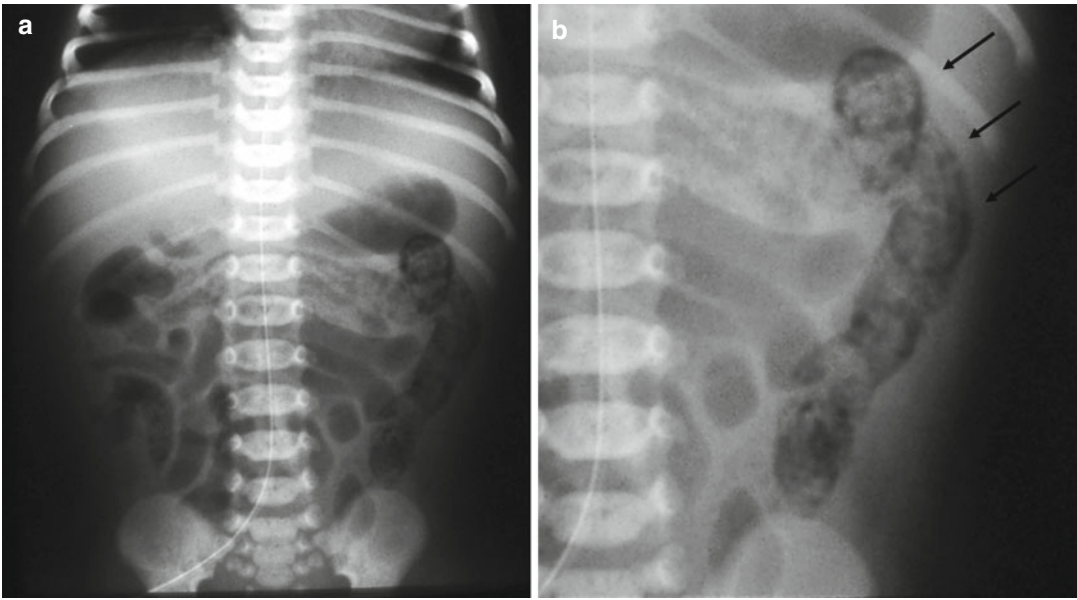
Abdominal plain film (a) in newborn with NEC and (b) magnification of the left quadrant: the thin radiolucent linear morphology located in the outer part and the surface of the bowel is the *curvilinear/linear* disposition
